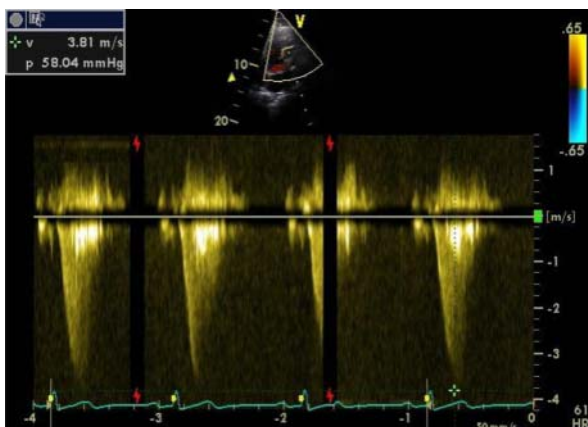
Continuous wave Doppler demonstrating right ventricular outflow tract obstruction.
